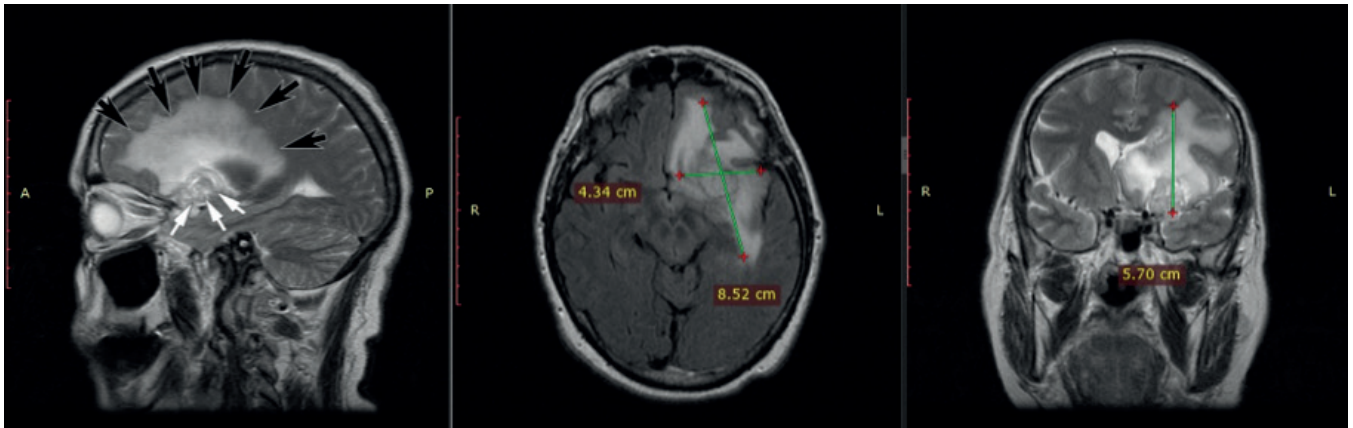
Preoperative brain T2-weighted MRI showed extensive PTBE, $4.3 \times 8.5 \times 5.7$ cm³, causing midline shift and mass effect. The mass (white arrow) is surrounded by massive edema (black arrow).
